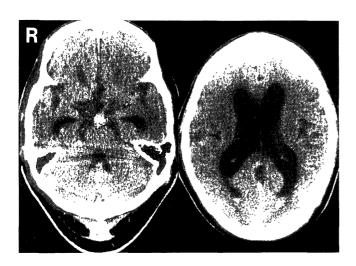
Computed tomography scans on admission revealing accumulation of blood in the interpedunclar cistern and sedimentation in both posterior horns of the lateral ventricle with mild ventricular dilatation, but no extension of blood to the sylvian fissures or the interhemispheric fissure.
